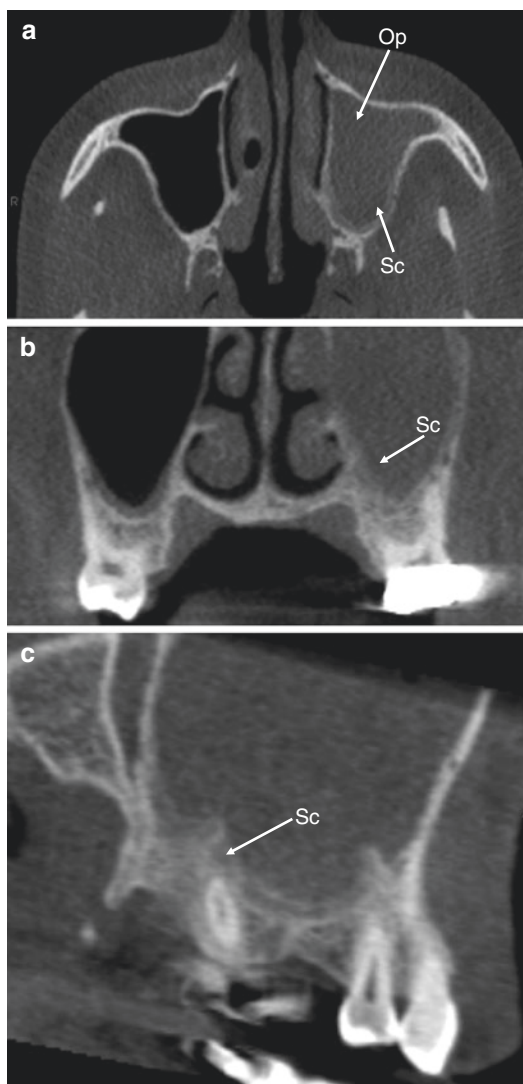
Coronal (a), sagittal (b), and axial (c) CBCT sections of the maxillary sinuses showing complete opacification of the left maxillary sinus and ostial blockage. This patient was symptomatic complaining mainly of fullness, pressure and pain
